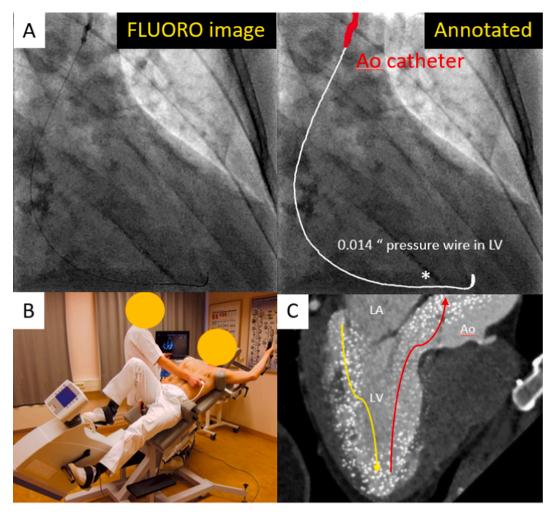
Panel A: invasive setup for SAVI measurements. Ao: Aorta. LV: left ventricle. Panel B: Supine ergometer stress set-up. Panel C: computed tomography based computational fluid dynamics analysis. LA: left atrium. Asterisk: pressure sensor.
